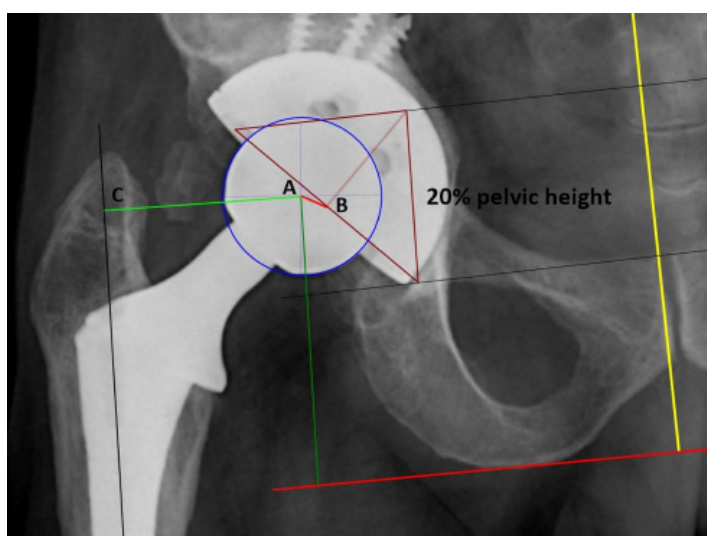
Measurements made on AP pelvic radiographs. The prosthetic hip joint rotation center (A), the native hip rotation center (B) according to the Ranawat method, AB line shows the distance between the prosthetic hip rotation center and the native hip rotation center, and the AC line shows the femoral offset
